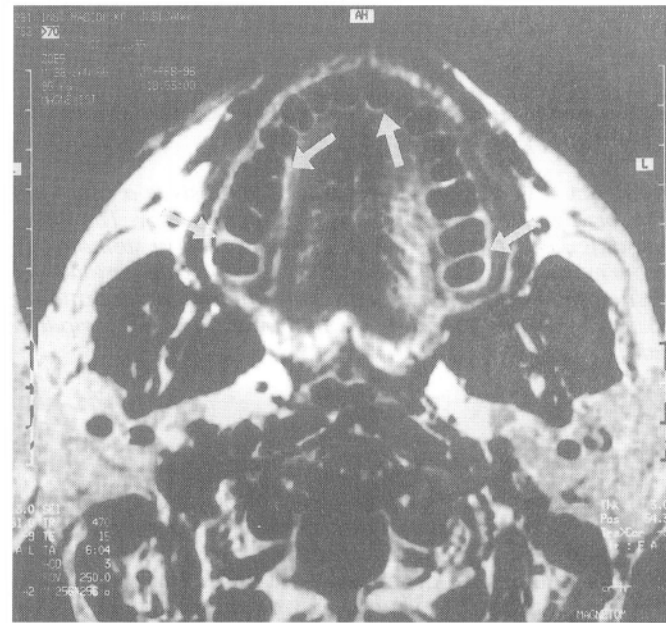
MR image of a 3 mm thick transversal slice through the maxilla. Contrast agent gadolinium-DTPA was used. The image is of the same slice as in Figure 2. The contrast between the inflamed and noninflamed tissue is increased.
